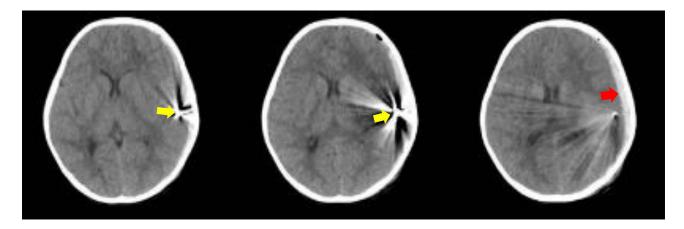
Figure I Multislice computed tomography revealed a bullet foreign body in the left temporal lobe (yellow arrow) and subdural hematoma (red arrow).
